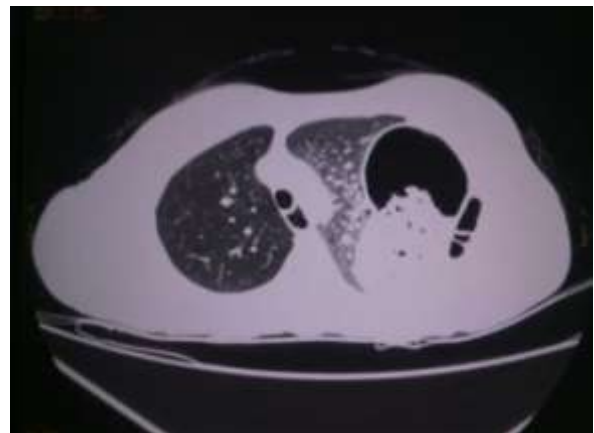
CT scan: Lung window shows stomach containing air and food material and large intestine with haustration.
